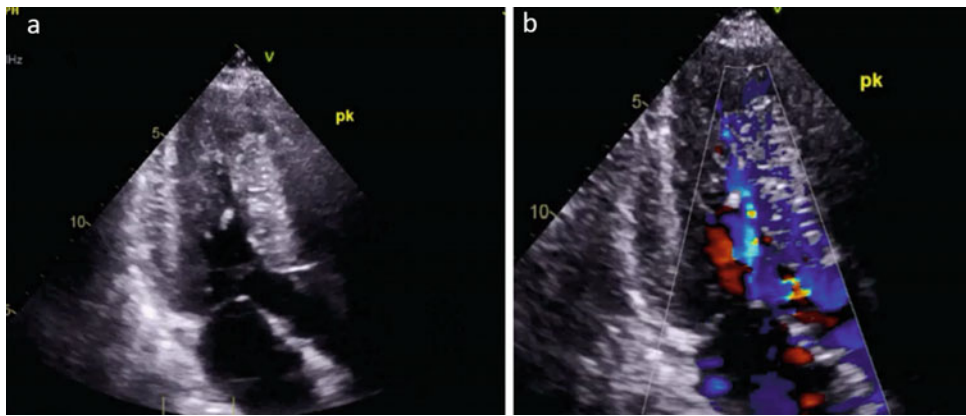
Bicycle stress echocardiogram. A. Apical three chamber view showing the presence of systolic anterior motion at peak exercise. B. Color Doppler shows evidence of turbulent flow across the LV outflow tract
